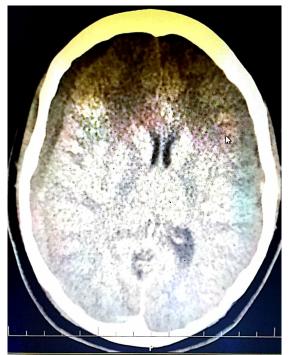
Computed tomography (CT) of the brain showing subdural hematoma
